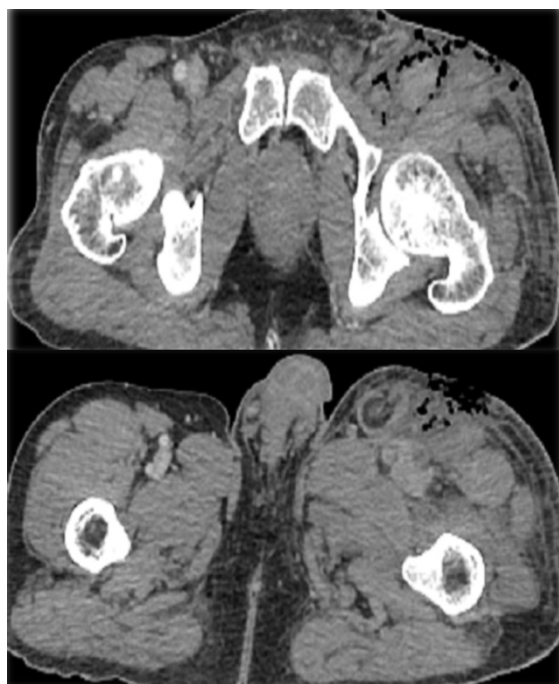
Computed tomography scan of the femoral area showing subcutaneous gas suggestive of necrotizing fasciitis.
